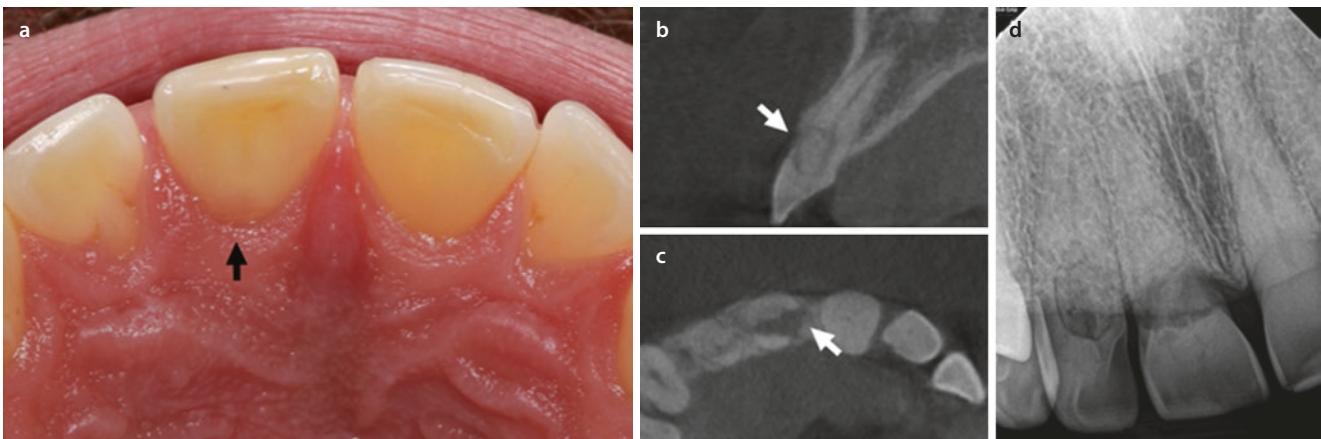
a Intra-orally, a pink hue (black arrow) is observed on tooth #8 with Class 3 ICR. The CBCT coronal b and axial c orthogonal planes show the portal of entry on teeth #7 and #8, respectfully (white
